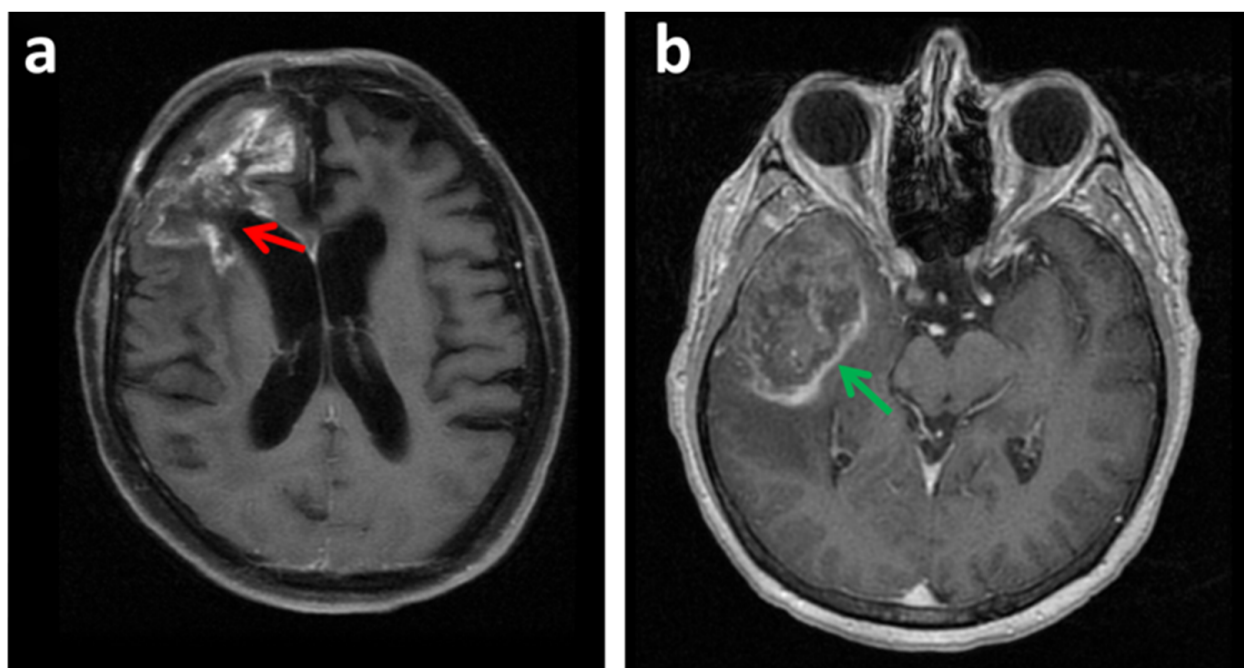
Other lesions can be confounding with glioblastoma. (a) Axial FS T1 MRI image with contrast of a glioblastoma recurrence (red arrow). In some situations, conventional MRI cannot correctly differentiate tumor tissue from post-therapeutic effects following neurosurgical resection and radiation. In this image, tumor recurrence was confounded with treatment necrosis produced by radiation. (b) Axial 3D Fast spoiled gradient echo (FSPGR) with MRI image. A patient suffering from hepatocellular carcinoma (HCC) presented one brain lesion detected by MRI (green arrow). In this situation a glioblastoma could be confounding with a brain metastasis. A biopsy indicated a glioblastoma and was discarded to be a brain metastasis from the HCC.
